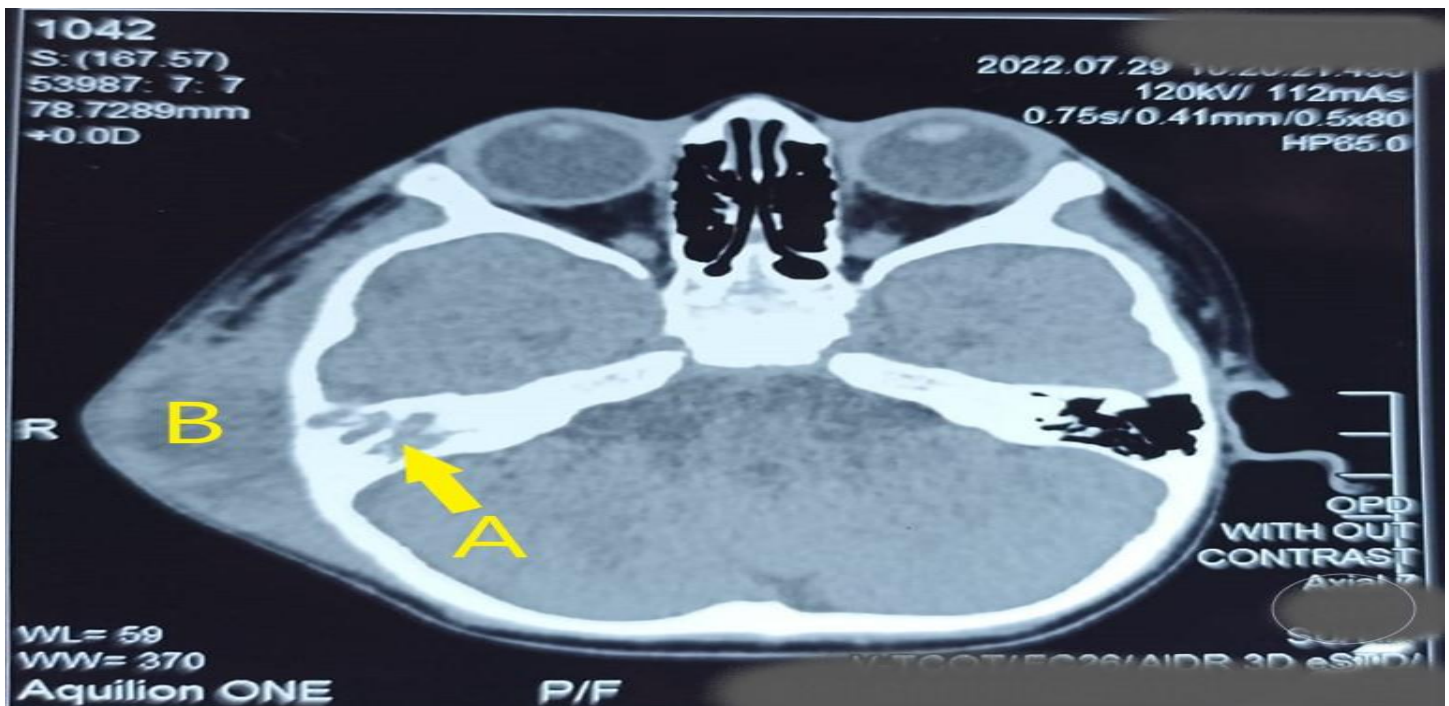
Subperiosteal Abscess: HRCT Temporal Bone revealing Right Otitis Media and Right Mastoiditis with osseous destruction of right mastoid temporal bone (A) and lateral extension to the postauricular soft tissue to form 4.0 x 3.3 x 2.3 cm fluid pocket/abscess (B). Left middle ear and mastoid air cavity seems normal.
